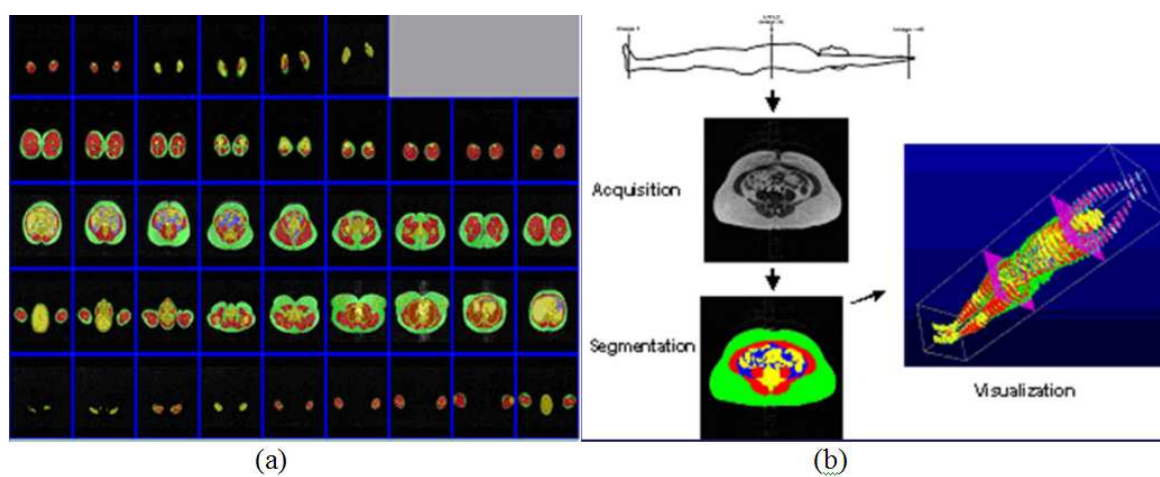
Obesity Research Center Integrated system for quantification of Adipose tissue from Whole Body MRI scans. Courtesy of Dr. Heymsfield.
